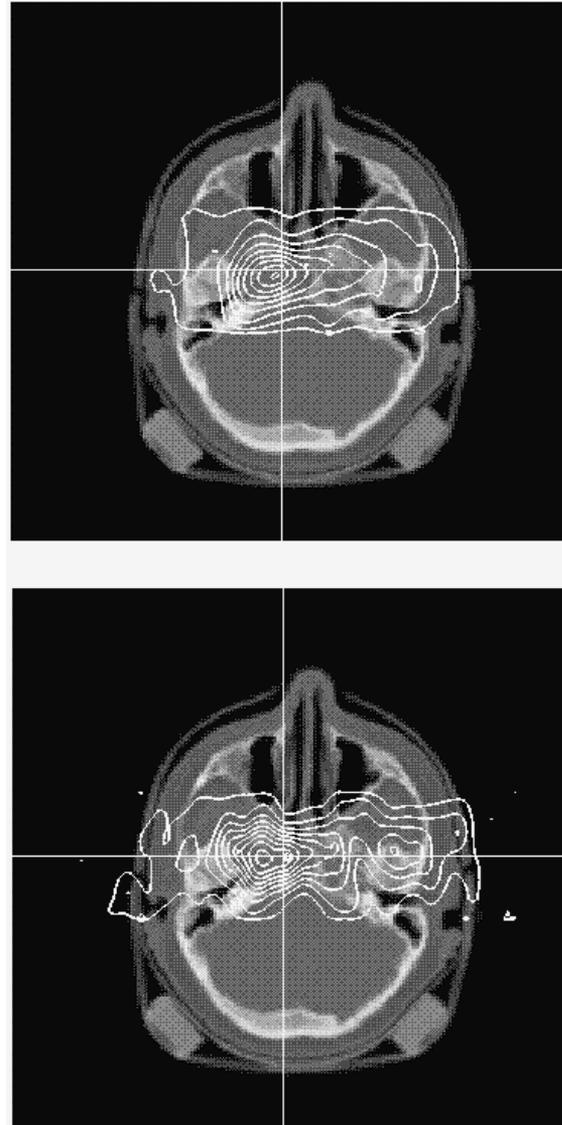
X-ray computed tomograms of a patient that has been irradiated with  $^{12}\text{C}$  in Dec. 1997. the upper contour plot shows the precalculated  $\beta^+$ -activity distribution, the lower contour plot shows the measured  $\beta^+$ -activity distribution. The isodose and isoactivity lines are spaced by 10% of the maximum value.
